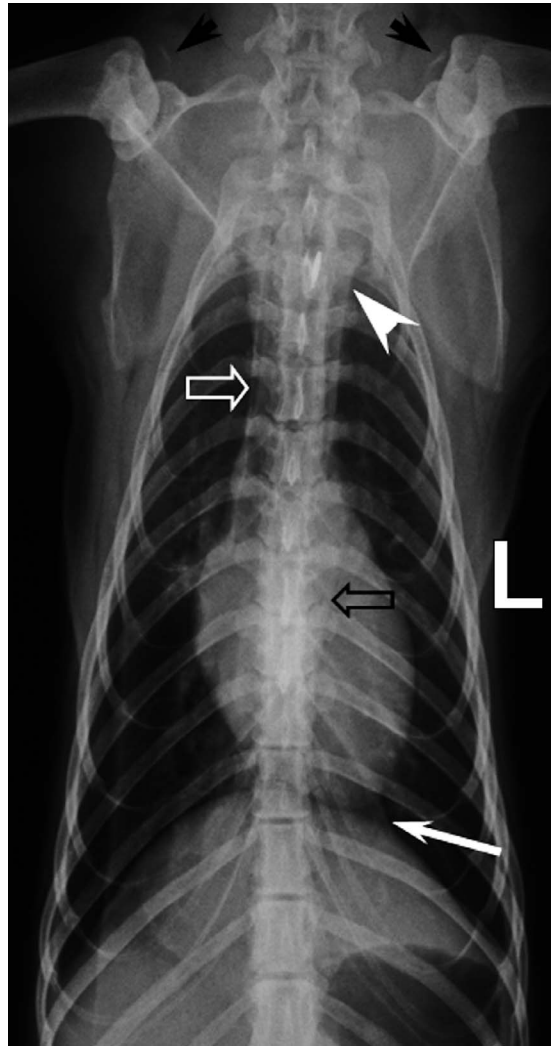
Dorsoventral thoracic radiograph of a 1.4-yr-old (5.6-kg) male red panda. Note the presence of the rudimentary clavicles (black arrows). The cardiac silhouette is ovoid and the apex is located in the left hemithorax. Note also the presence of minimal cardiodiaphragmatic contact. The trachea is positioned slightly to the right of the spine (open white arrow). The craniodorsal mediastinum is wider than the thoracic spine (white arrow head). The left margin of the descending aorta and the caudoventral mediastinal reflection are indicated by an open black arrow and a white arrow, respectively. L = left.
